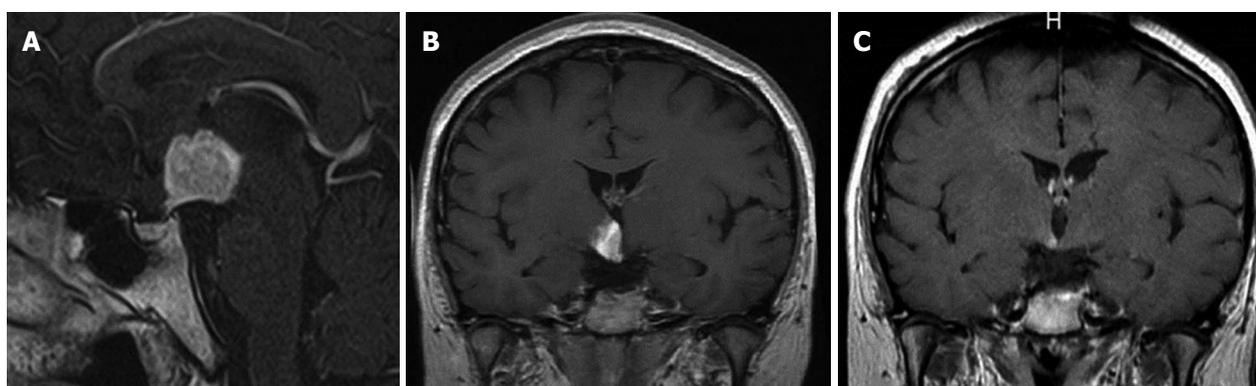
Langerhans cell histiocytosis mass at the hypothalamic area (A) and hypothalamic–pituitary area, comparison of pre and post chemotherapy (B, C). A: Gadolinium-enhanced magnetic resonance imaging (W1T1) shows a large mass at the hypothalamic area. Pituitary stalk is enlarged; B, C: Gadolinium-enhanced magnetic resonance imaging (T1W1) shows (B) a large mass before chemotherapy and (C) a residual mass post chemotherapy. The size of mass was significantly reduced after 2-deoxychloroadenosine treatment.
